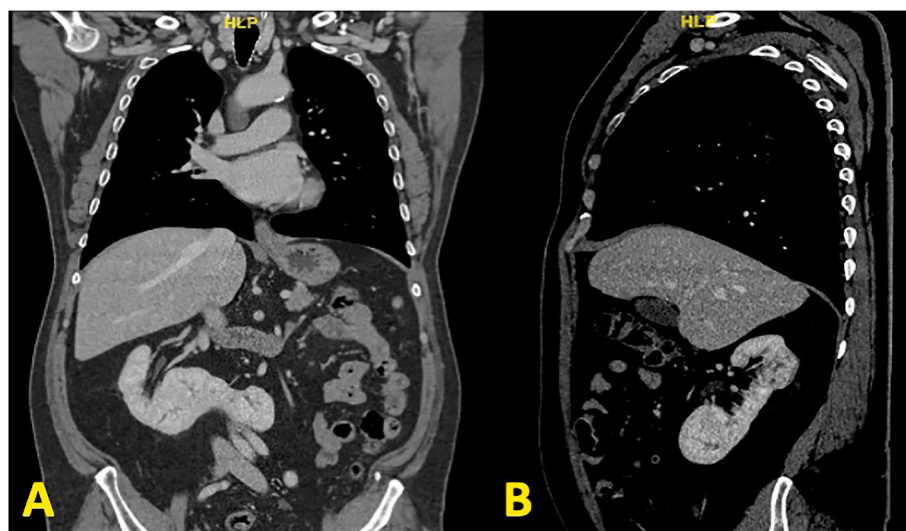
A; Preoperative Abdominal Pelvic CT with contrast (A) Coronal view, showing the ectopic left kidney fused to the lower pole of the right kidney. (B) Sagittal view, showing a renal mass in the upper pole of the right kidney.
